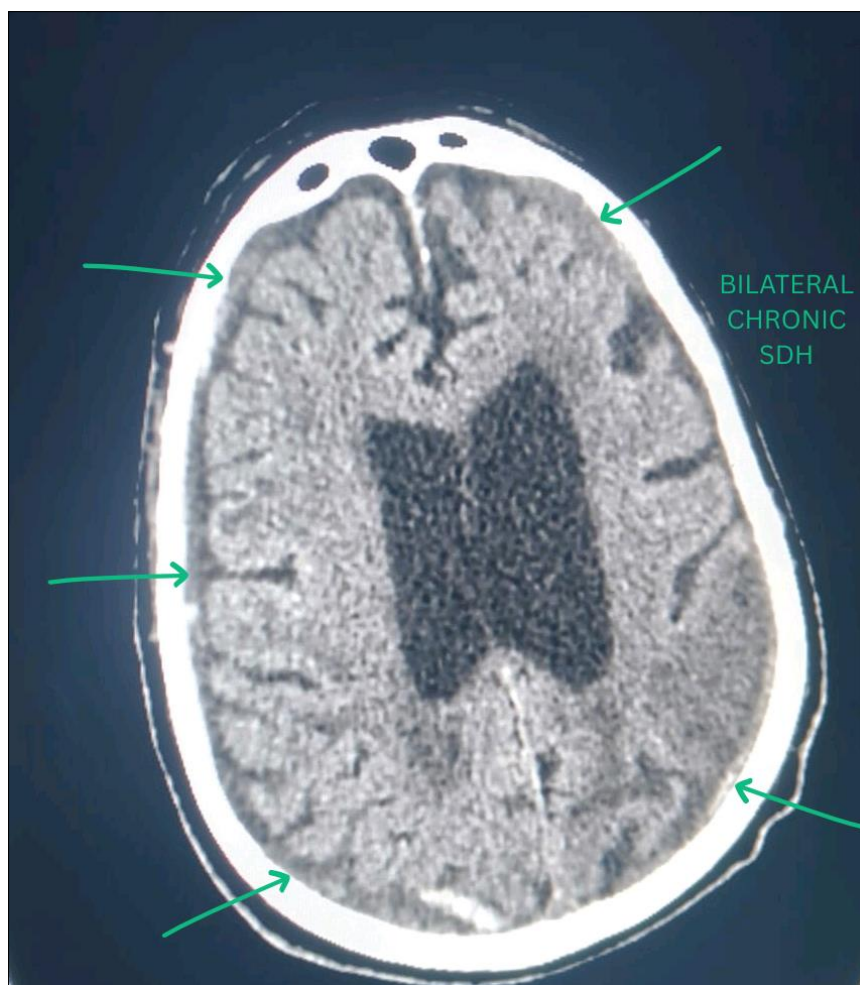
Initial CT scan image showing bilateral chronic SDH
